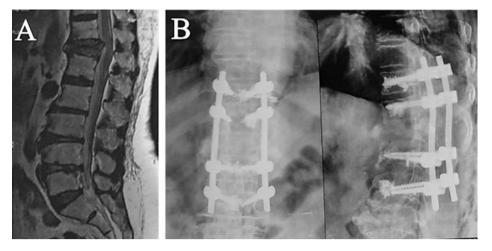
A 63-year-old female patient with an osteoporotic D12 compression fracture: (A) preoperative sagittal T2 MRI showing marked reduction of D12 vertebral body height; (B) 6-month postoperative plain radiographs in anteroposterior and lateral views showing shadows of bone cement within the vertebral bodies around the screws, with a small amount of paraspinal leak opposite DV 10.
